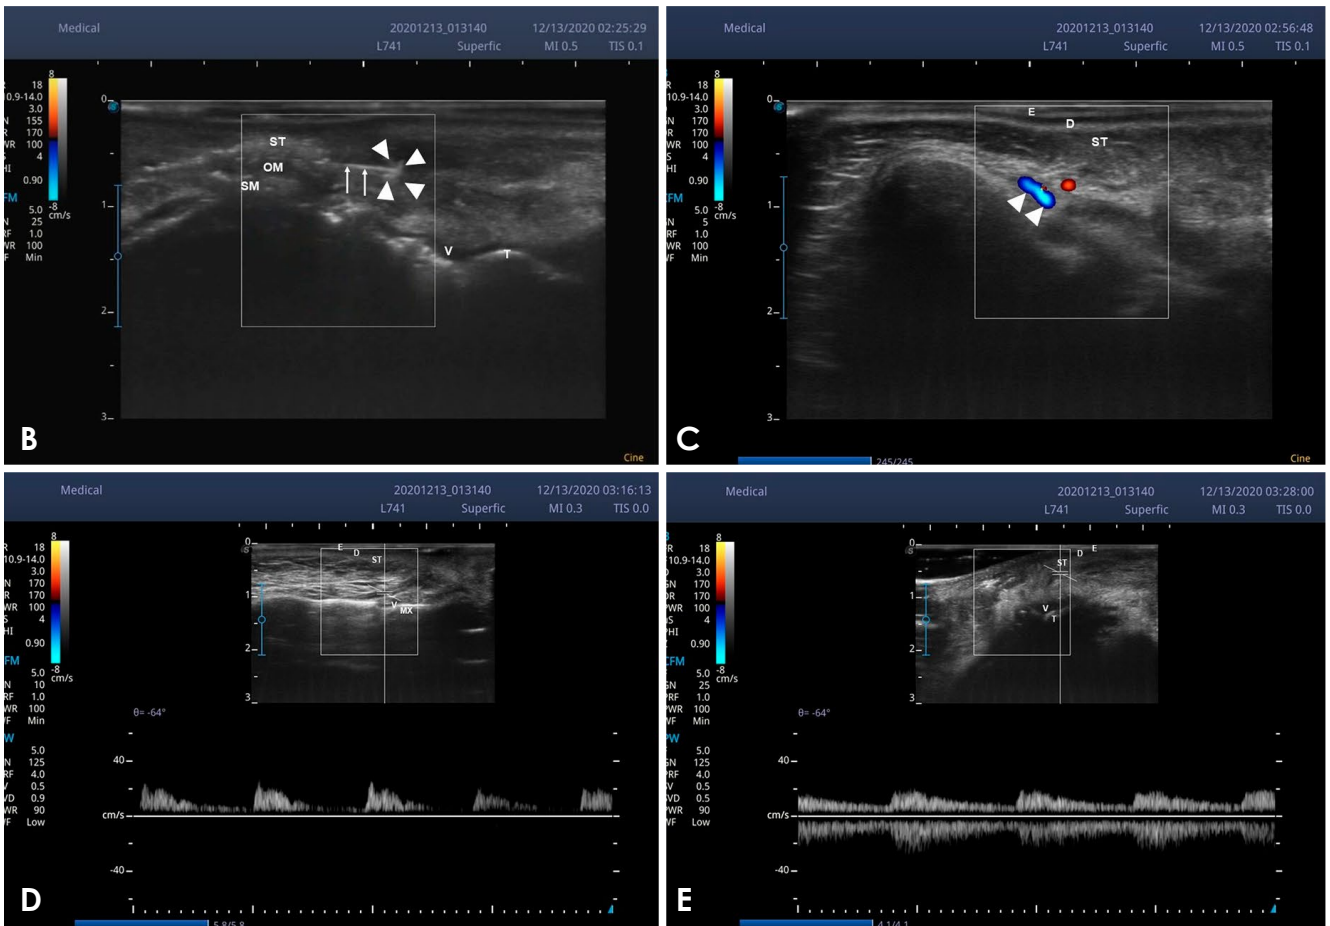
Ultrasonographic images of the patient's face before applying hyaluronidase. A. Ultrasonographic image of the right upper lip region, with the transducer in a transverse position, demonstrating a hypoechoic area (N) in close proximity to the facial artery (▲) (Doppler). B. Transducer with transverse positioning, showing reduction in blood flow on Doppler. C. Doppler ultrasonographic image of the right upper lip region (nasolabial fold), with the transducer in an oblique position, showing impaired blood flow. D. Doppler ultrasonographic image of the right angular artery with the transducer in a longitudinal position, showing reduction in blood flow. E. Doppler ultrasonographic image of the medial corner region of the orbit on the right side, with the transducer in a longitudinal position, showing unchanged blood flow from the venous return of the angular vein. F. The transducer in a transverse position, showing an image of the upper left lip wherein blood flow is not compromised in the superior labial artery (▲▲). E: epidermis; D: dermis; ST: subcutaneous layer; OM: orbicularis oris muscle; SM: submucosa; V: vestibule; T: teeth; (+): meeting of fibers coming from the zygomaticus major, elevator of the upper lip and elevator of the angle of the mouth muscles; MX: maxilla; ▲▲: superior labial artery; small arrows: angular artery; FB: frontal bone.
